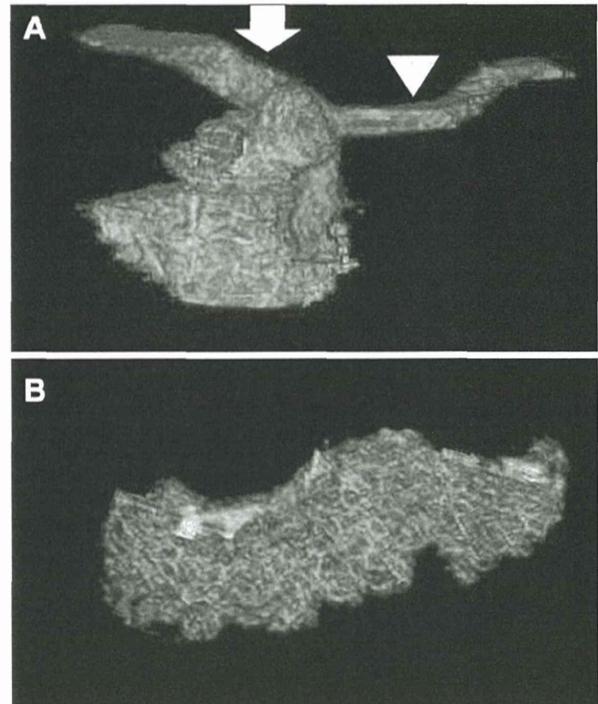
Preoperative images of three-dimensional computed tomography pancreatic volumetry. (A) The pancreatic head is outlined by the left edge of a superior mesenteric vein (arrow) conjoined with a splenic vein (arrowhead). (B) A pancreatic body-tail as an allograft.
